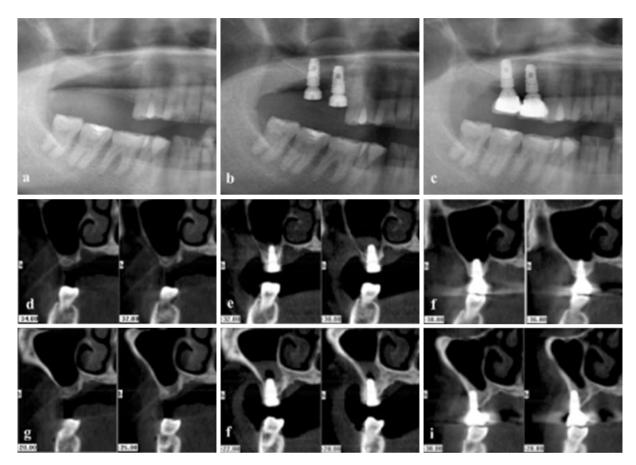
Radiologic responses of the elevated sinus membrane after hydraulic lifting of sinus membrane without bone grafts. Panoramic images at T0 (a), T1 (b), and T4 (c); Coronal CBCT images of the right maxillary second molar implant area at T0 (d), T1 (e), and T4 (f); Coronal CBCT images of the right maxillary first molar implant area at T0 (g), T1 (h), and T4 (i).
